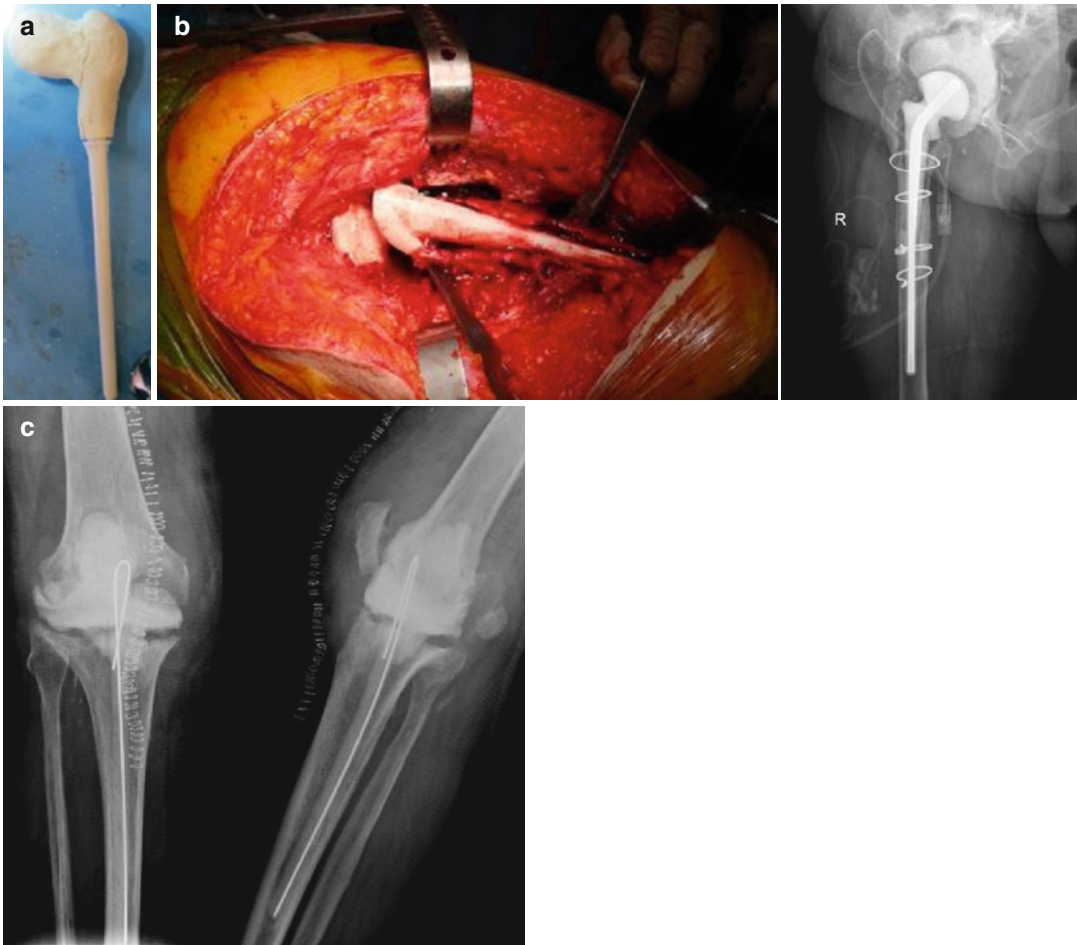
Examples of spacers. (a) Hand-made hip spacer; (b) Pre-manufactured hip spacer- intra-operative photograph and post-operative X-ray view; (c) Static knee spacer with intramedullary antibiotic rod extension
